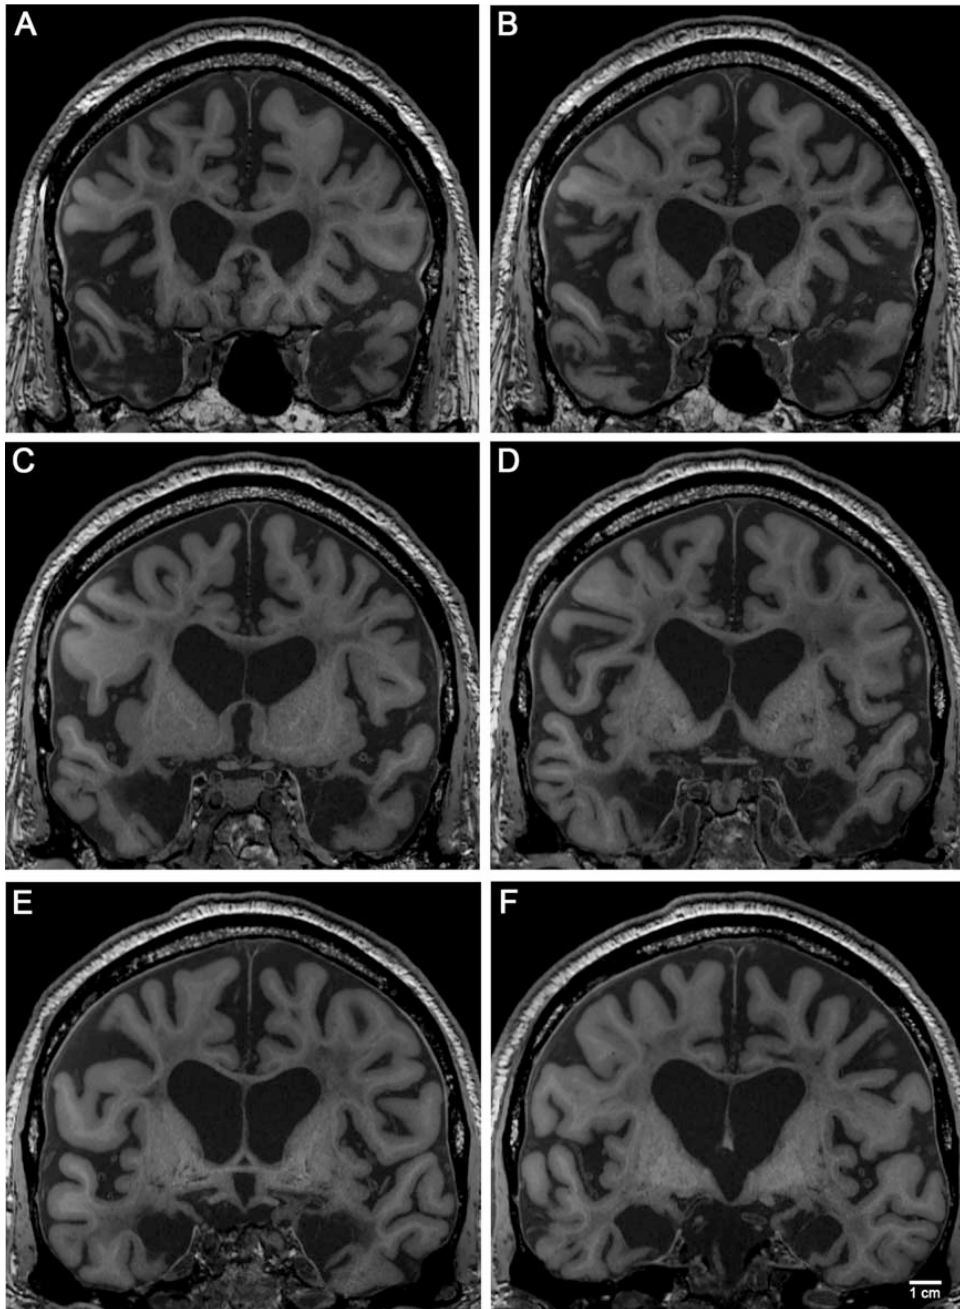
Various MRI contrasts acquired at 3.0 T in situ. (A) multiecho MPRAGE (MEMPR), (B) T2-SPACE, (C) T2-SPACE FLAIR, (D) quantitative PD, (E) quantitative T1, (F) synthetic FLASH. Note the lesion in all contrasts, with the borders especially clear in the multiecho MPRAGE and synthetic FLASH images. T1 and T2-SPACE FLAIR revealed scar tissue faintly in addition to the lesion.
